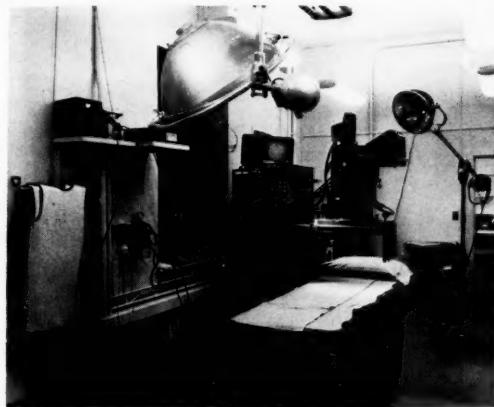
Cardiological X-ray apparatus with television and electronic monitoring devices in the cardiac catheterization laboratory.
